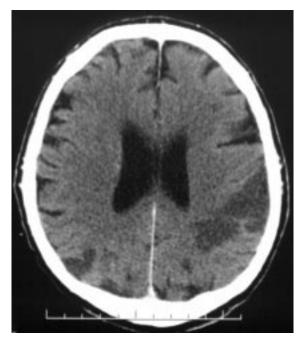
Cerebral CT scan of a patient with a massive stroke caused by crossclamping a severely atherosclerotic ascending aorta. Note the extensive ischemic areas in both hemispheres.
